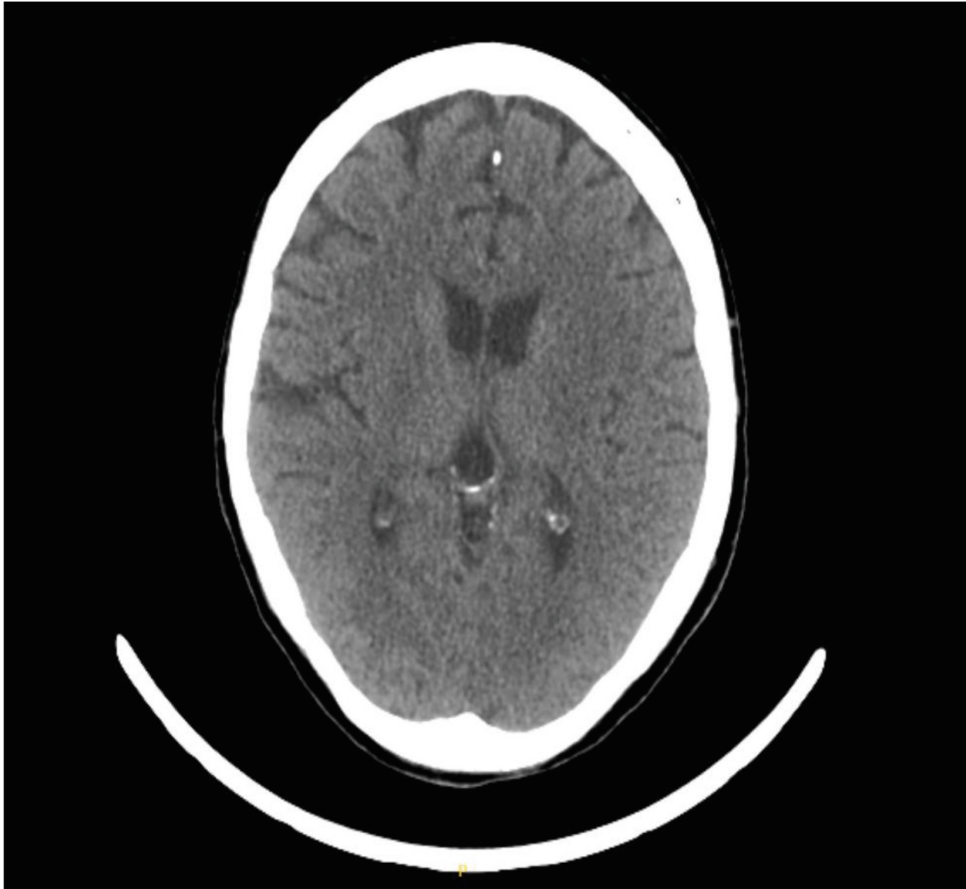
Follow-up CT brain showing regression of previous signal changes.
